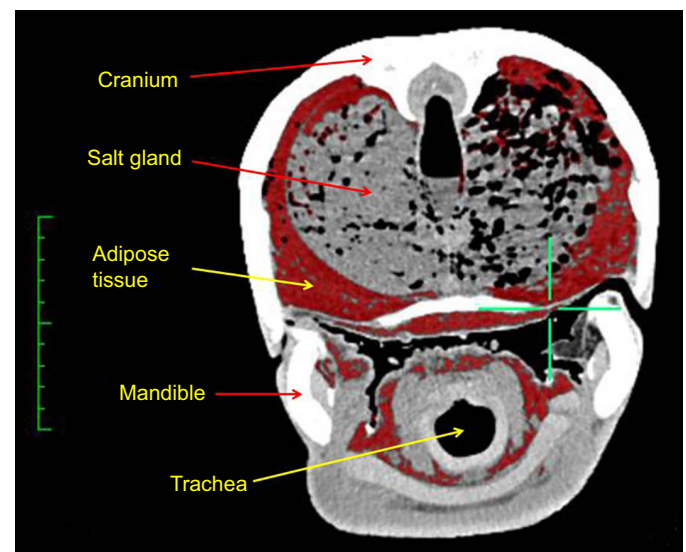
Labelled tranverse computed tomography image of the head of an adult *Dermochelys coriacea*. Left-hand scale=10×1 cm.
